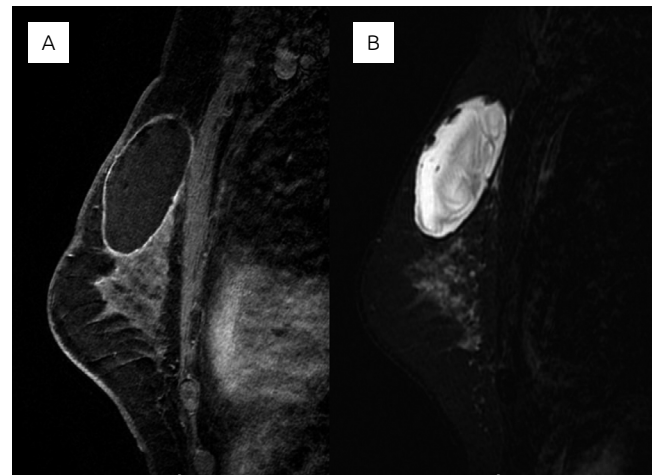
Breast magnetic resonance imaging (MRI) shows a well-encapsulated cystic mass with thin walls and content with low signal at T1-weighted images (A) and heterogenous high signal on T2-weighted images, presenting linear hypointense images inside it (B).
